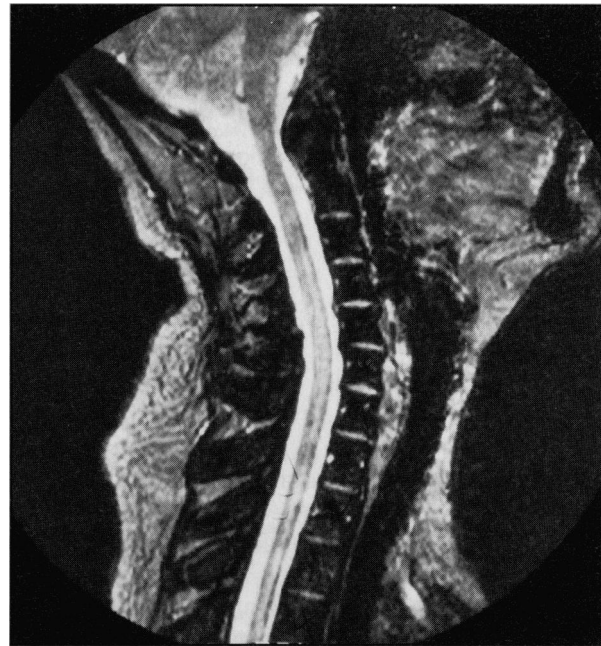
Magnetic resonance image of the spinal cord (T1-T5) showing resolving linear lesions to the left of the midline with resolving edema.
